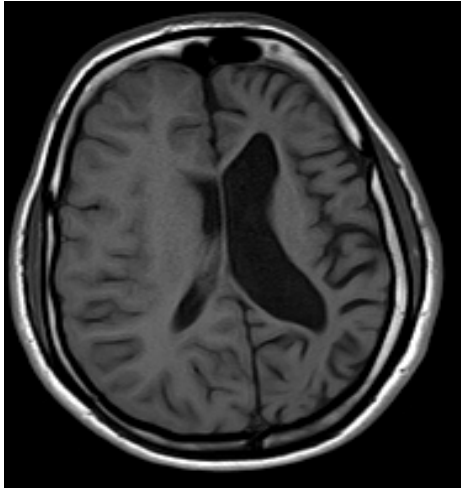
T1W image and Fig 2 T2W image of axial section MRI brain shows left cerebral hemiatrophy with dilatation of the left lateral ventricle
